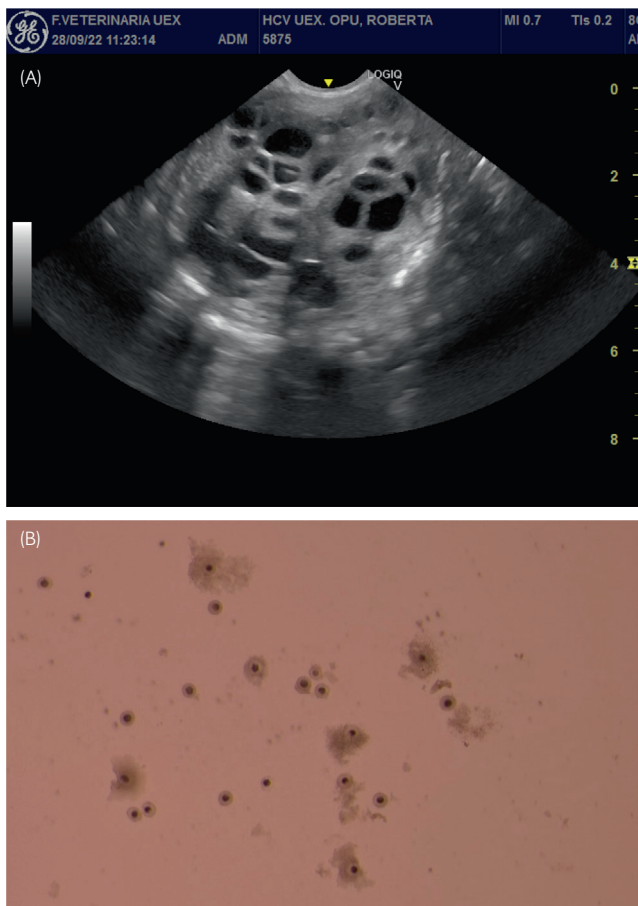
Ultrasonographic image of Case 2's ovary, and oocyte recovery 1 year after treatment of the abscess. (A) Transvaginal ultrasonography of the left ovary with normal ovarian activity. (B) Oocytes recovered by ovum pick up from the same mare.
